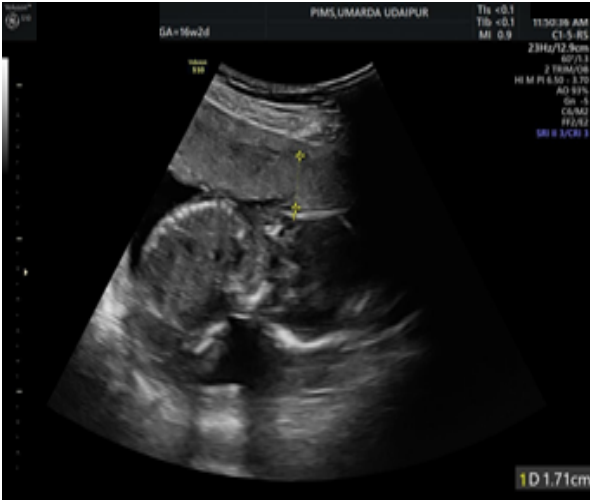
Transabdominal sagittal sonographic image at 16 weeks 2 days of gestation demonstrating placental thickness measurement (calipers) at the level of umbilical cord insertion. The placenta is seen along the anterior uterine wall, with a measured thickness of 1.71 cm.
